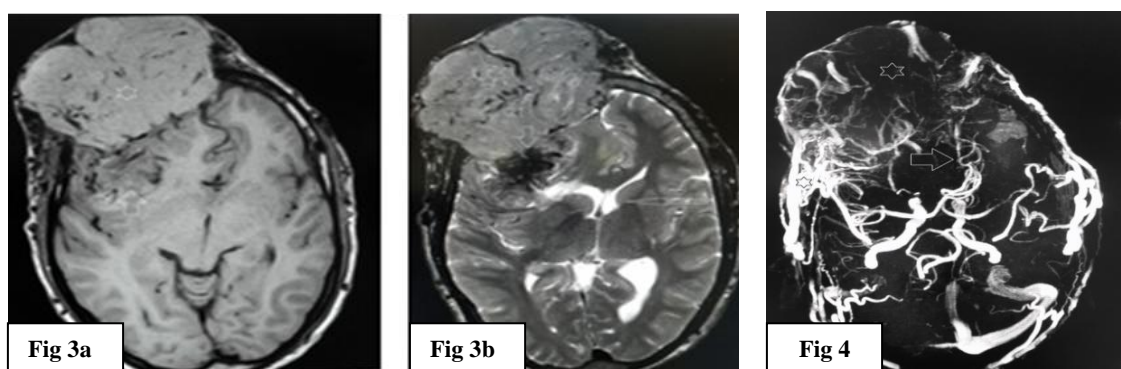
MRI Head. 3a - T1W plain axial section shows extracranial non-homogenous iso-intense component (white star) with intracranial hypointense part (vertical up arrow) and many flow voids. 3b - T2W axial section shows iso to slight hyperintense mass (white star) with inhomogenous hypointense intracranial part (white down arrow). There is mass effect leading to midline shift (horizontal white arrow). Figure 4 - TOF MR angiography shows multiple draining veins at the interface of the mass (black star) and displacement of ACAs to the left side (white arrow).
